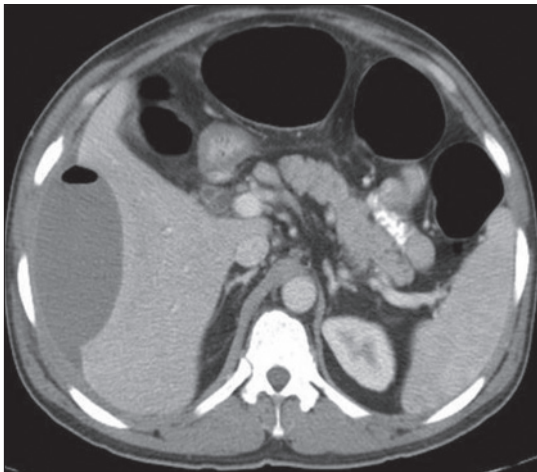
Contrast-enhanced computed tomography scan showing subcapsular hematoma with air foci
